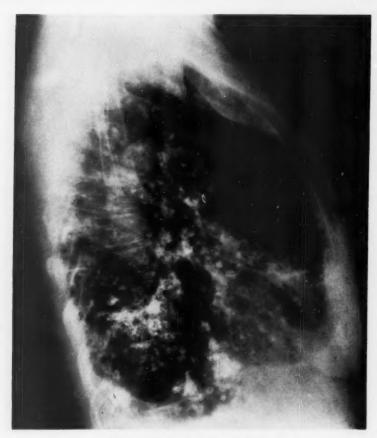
Chest x-ray, May 3, 1958.
